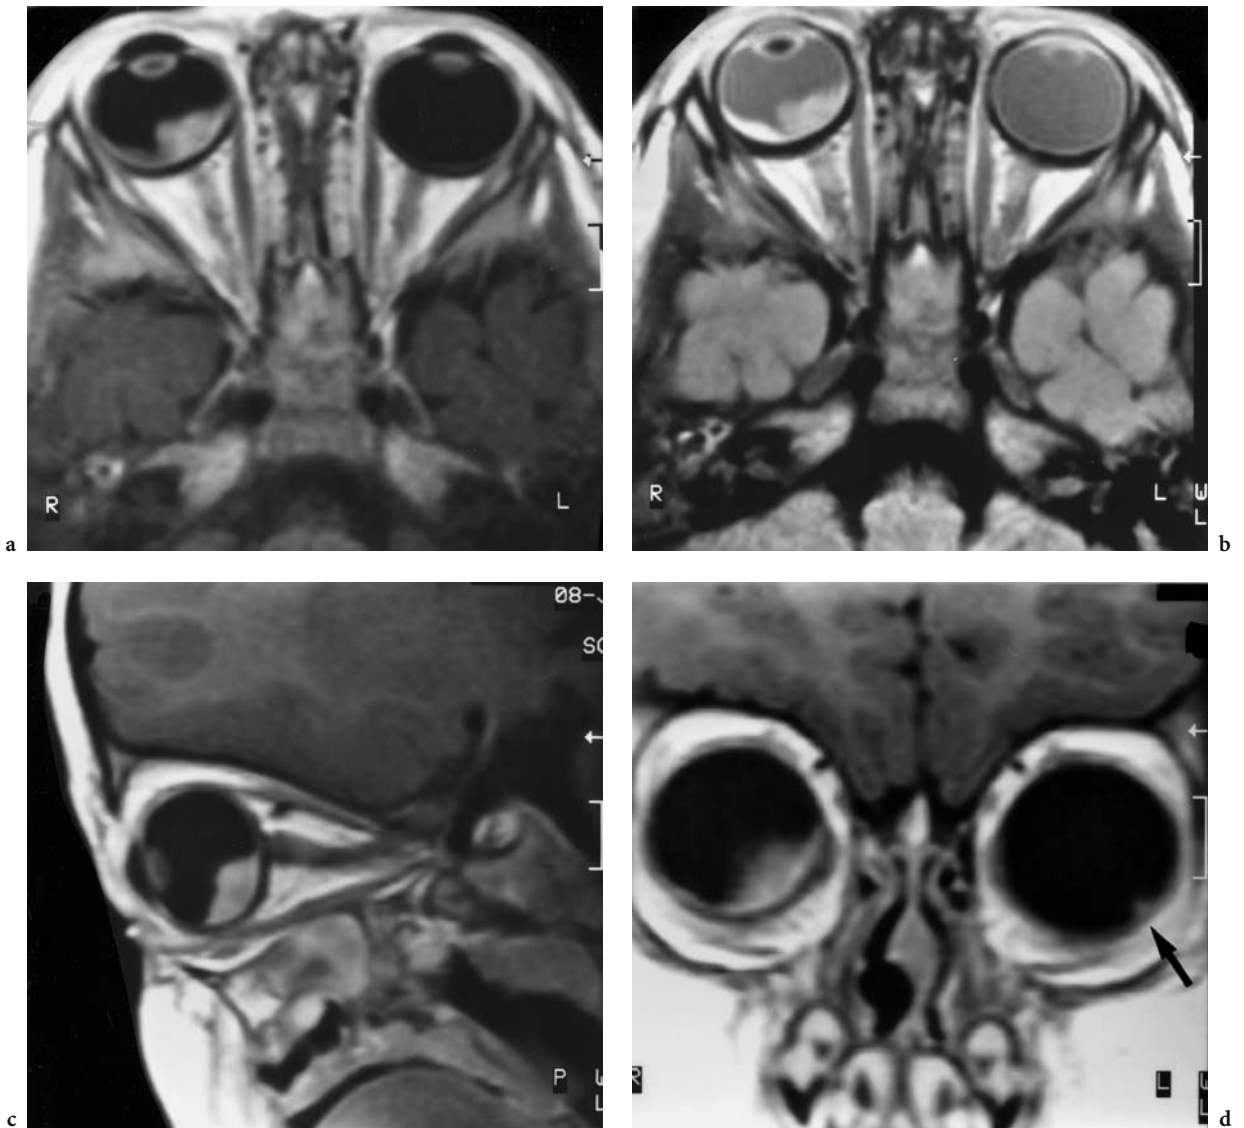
A 1-year-old girl with leukokoria of the right eye. Diagnosis: bilateral retinoblastoma. Triplanar MRI (surface coil over both orbits): a Axial T1-weighted, contrast-enhanced image showing the hyperintense tumor crossing the optic nerve in the medial and posterior region of the right globe. The crescent-shaped, less hyperintense lateral pathology corresponds to a retinal detachment, more readily identified as (hyperintense) fluid and differentiated from the solid tumor in b, the corresponding proton-weighted image. c Sagittal paramedian T1-weighted, contrast-enhanced image confirming an intact optic nerve, even though the tumor has crossed it, an important finding of prognostic and therapeutic value. d Coronal T1-weighted, contrast-enhanced view enabling detection of a second tumor in the inferior lateral part of the contralateral globe (*arrow*)
